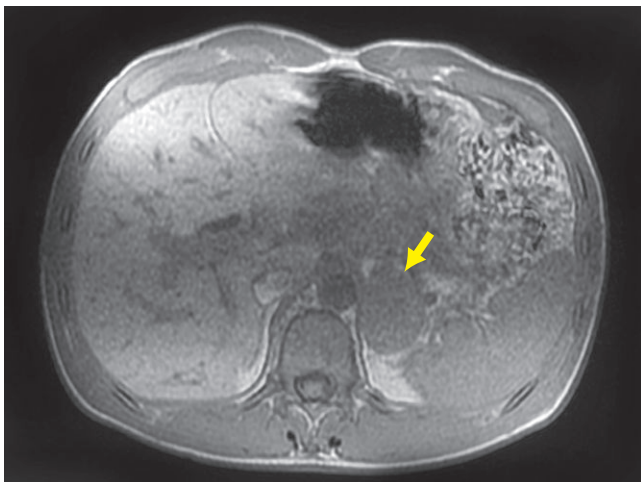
In-phase MRI of left adrenal in another patient (arrow).
